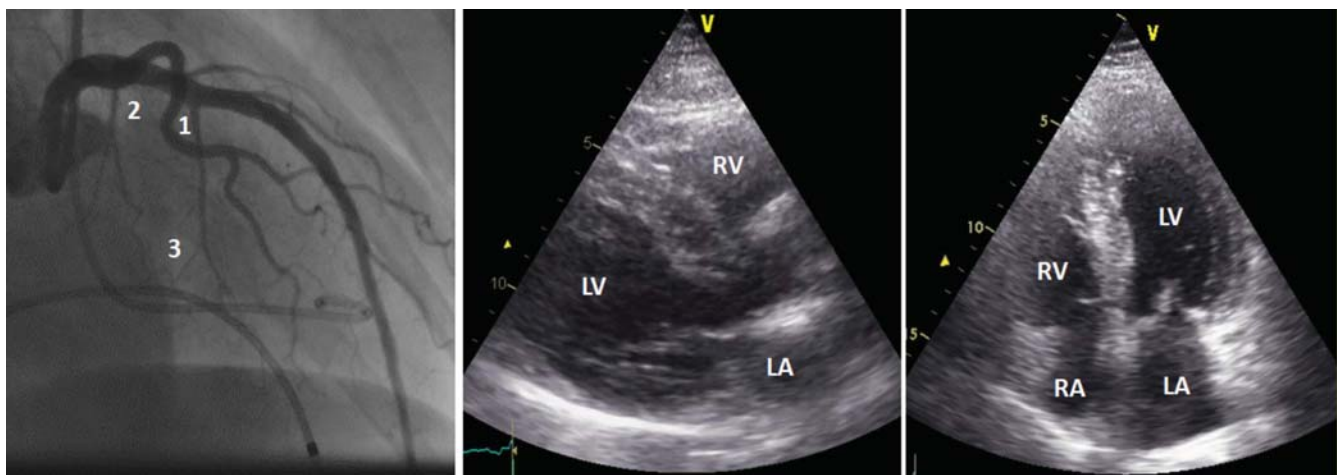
Left coronary angiography (left) shows a dominant septal branch (1) and a tiny proximal septal branch (2). The large septal branch (1) is divided in several ending branches, two of which are pointing proximally (3). Transthoracic echocardiography before alcohol septal ablation shows the typical septal hypertrophy in long axis parasternal (middle) and apical 4-chamber (right) views. LV: left ventricle, RV: right ventricle, LA: left atrium, RA: right atrium.
